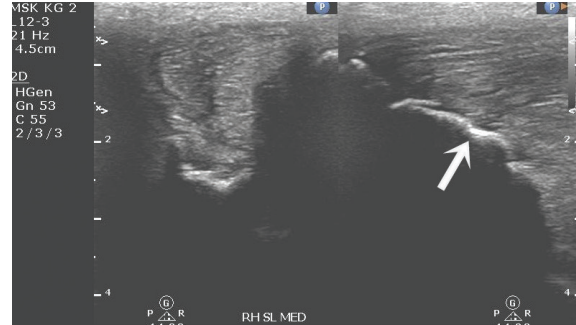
Post-operative (20 wk) ultrasound scan of the SBL ligament-bone interface (arrow points to healed injury site).
